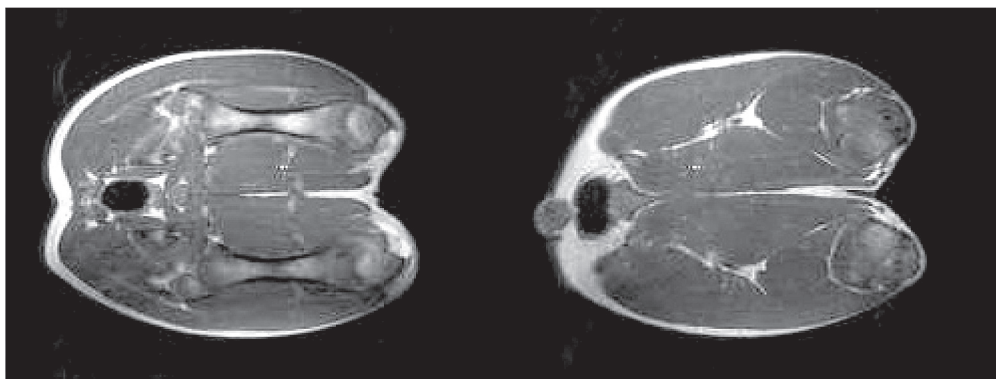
MR image of carcass cross-section in the ham area
